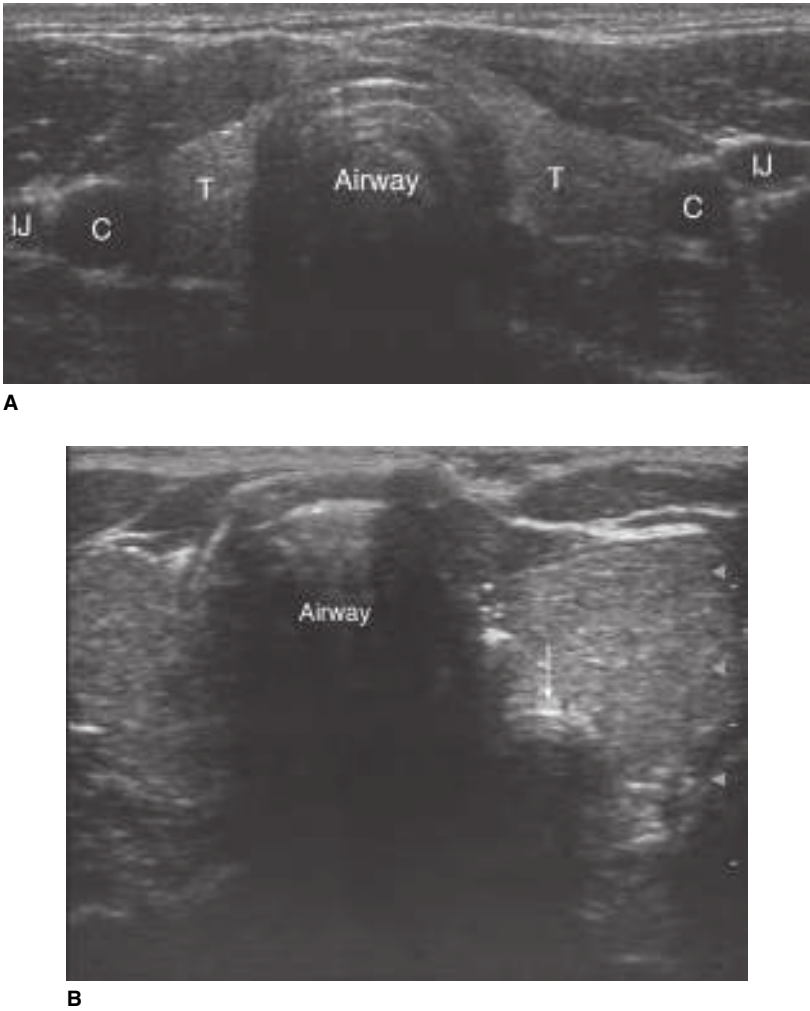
Ultrasound images at the level of the sternal notch to confirm proper ET tube placement. A. Endotracheal intubation. The signature double echo of the plastic ET tube can be seen in the airway or trachea. (C, carotid artery, IJ, internal jugular vein, T, thyroid gland.) B. Esophageal intubation. The ET tube (arrow) is in the esophagus. It is positioned deep and lateral to the airway. (Ultrasound images courtesy of Sam Hsu, MD.)
